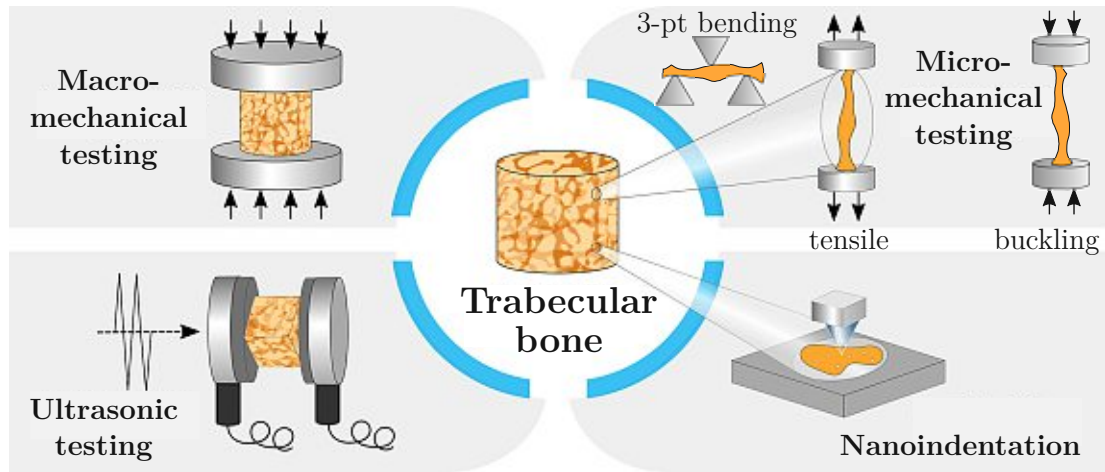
Mechanical characterization of trabecular bone tissue, image modified from Wu et al. [11]. Macro-mechanical testing, paired with FE analysis, is used to back-calculate tissue elasticity. Ultrasonic testing enables determination of elasticity, as speed of sound is dependent on tissue elastic properties. Micro-mechanical testing determines tissue properties directly from an experiment, such as a tensile, buckling or three point-bending test. Nanoindentation is used to measure elastic properties at the scale of individual lamellae.
